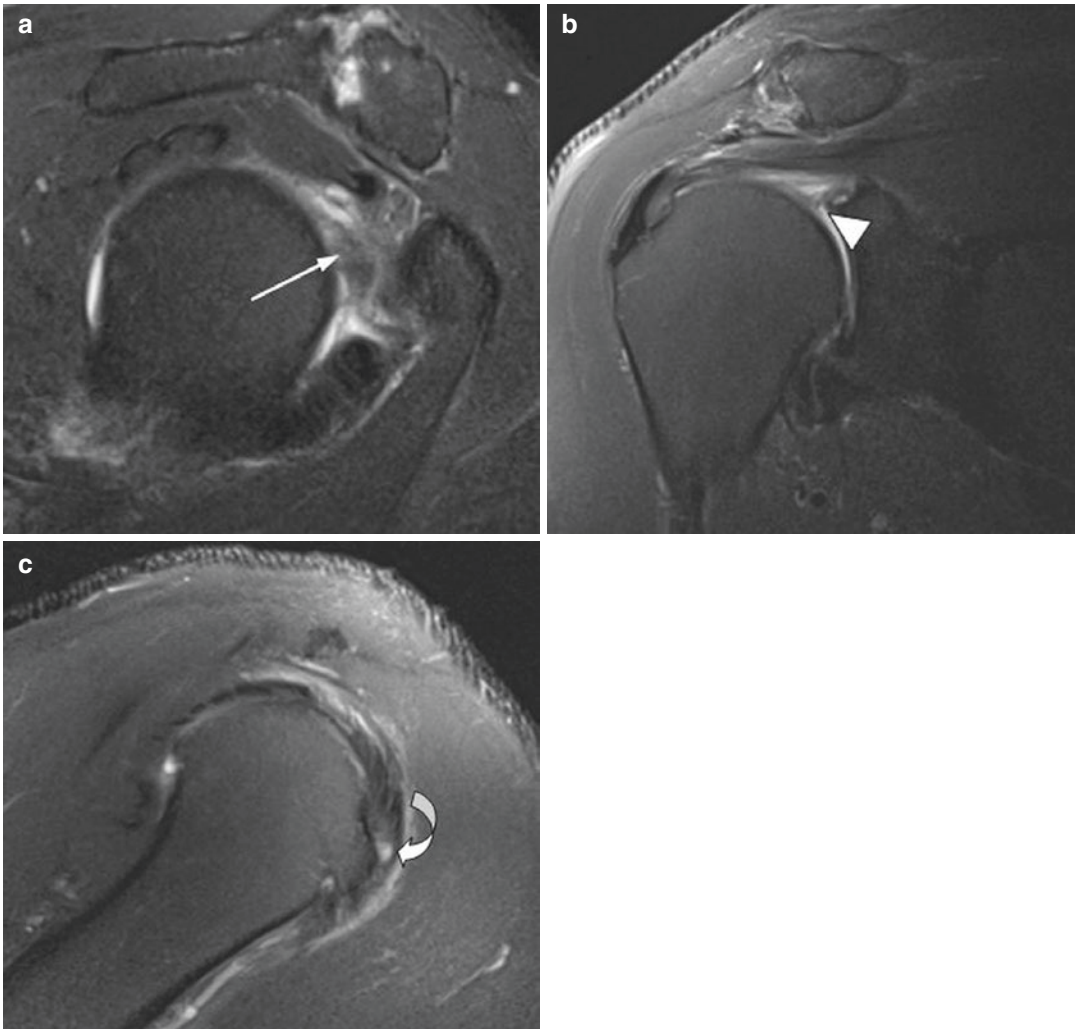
60-Year-old male with shoulder pain. (a) Sagittal fat-suppressed T2-weighted image demonstrates absence of the biceps tendon, coracohumeral ligament, and superior glenohumeral ligament (SGHL) in the rotator interval (arrow), consistent with tears. Instead, debris and organizing hemorrhage fill the rotator interval. (b)
